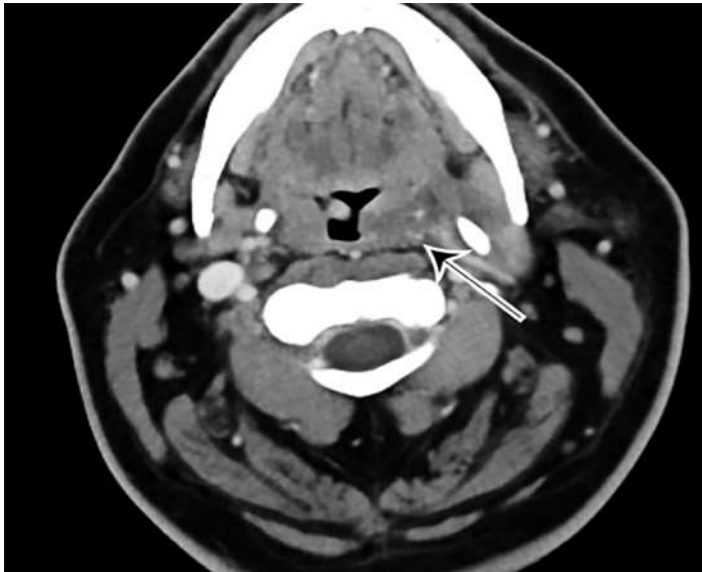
Computed tomography of the neck with intravenous contrast in axial view showing fluid tracking along the fractured left styloid process producing a mass effect on the left lateral hypopharyngeal wall, indicated by arrow.
